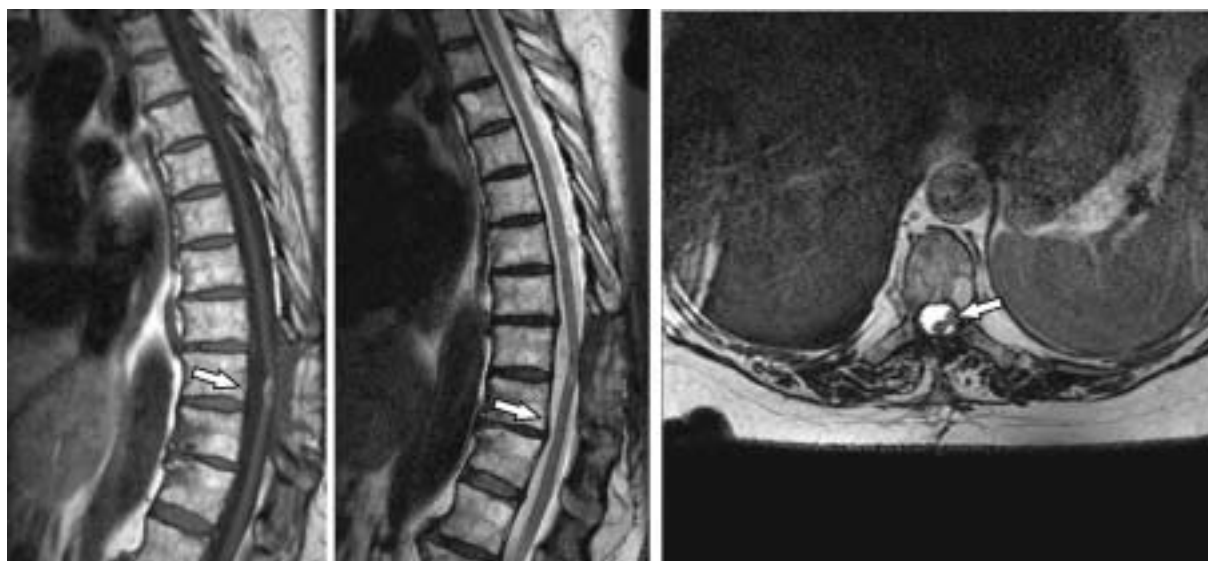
Follow up MRI examination one month after second surgery. Presence of tumor remnants (arrow).
